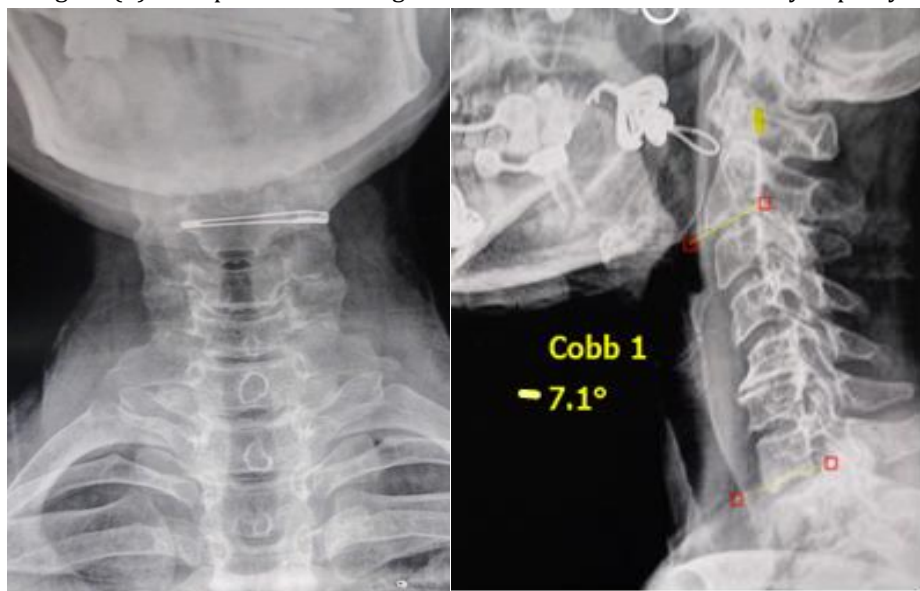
Preoperative X-rays AP and lateral view Cobb angle was -7.1° .
